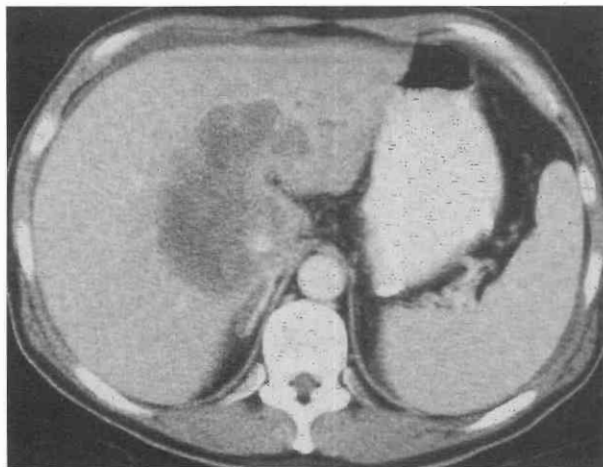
Intrahepatic cholangiocarcinoma in a 45-year-old man. Contrast-enhanced CT scan demonstrates a large central, predominantly hypointense mass with peripheral enhancement. The lobulated mass encases the inferior vena cava, which remains patent.
